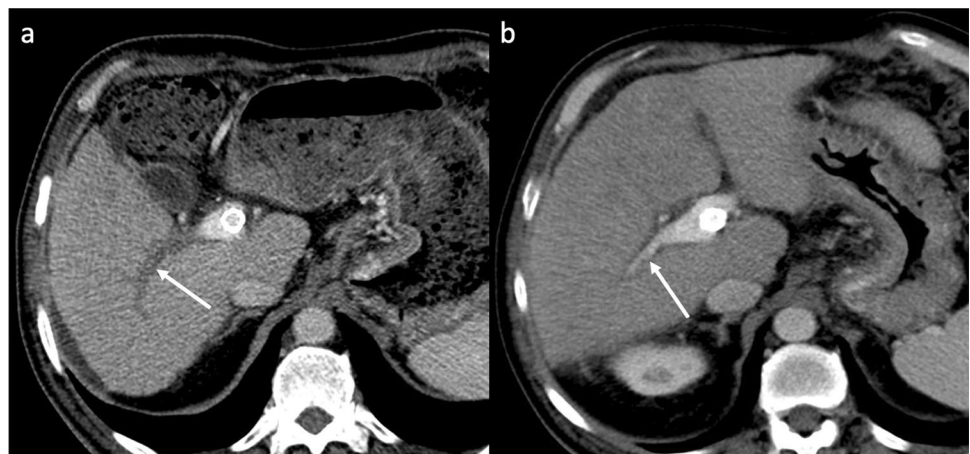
Portal vein thrombosis. Pre-procedure CT images in the portal venous phase (a, b) show left portal vein patency and partial thrombosis of the main portal vein (arrows). On the contrast-enhanced CT
